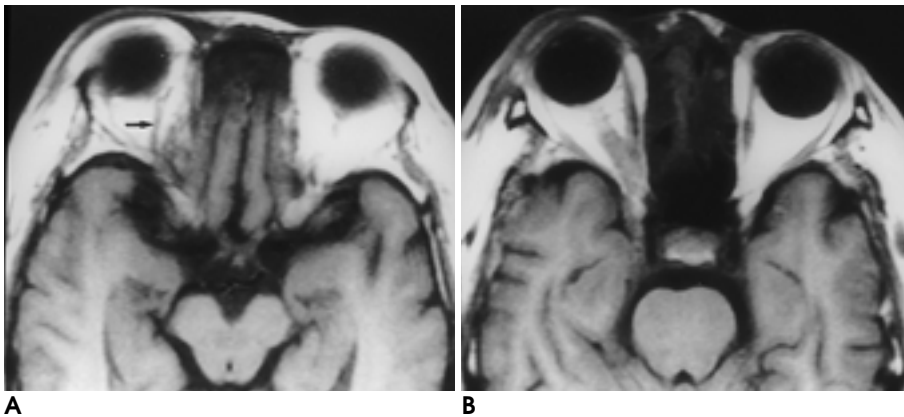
Case 4 (64/F) with right septic cavernous sinus thrombosis. Axial T1-weighted image (A) shows engorgement of right superior ophthalmic vein (arrow). Another axial T1-weighted image (B) is 1cm caudal section from A shows prominent right proptosis.
